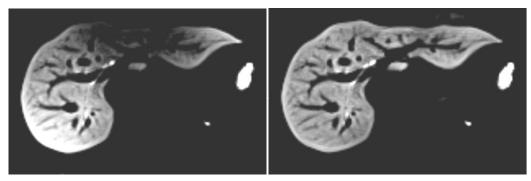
Elimination of inhomogeneities in MRI data: Original slice of a T1 weighted abdominal MRI with Gd-EOB-DTPA as contrast agent (left) and same image slice after application of the correction filter N3 with identical contrast and brightness parameters (right).
